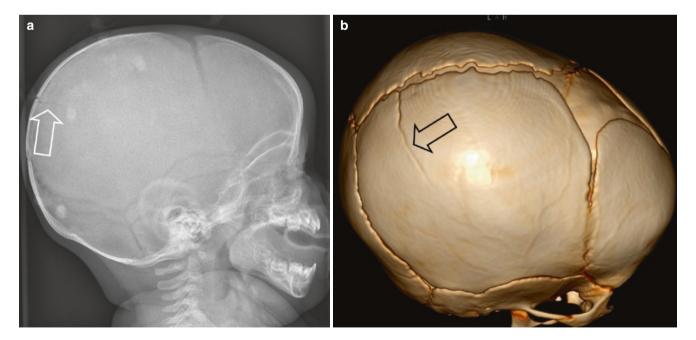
Six-month-old infant who fell from a baby changing table. (a) Conventional radiograph shows a linear skull fracture (arrow). (b) 3D-CT provides a better overview of the extent of the fracture
